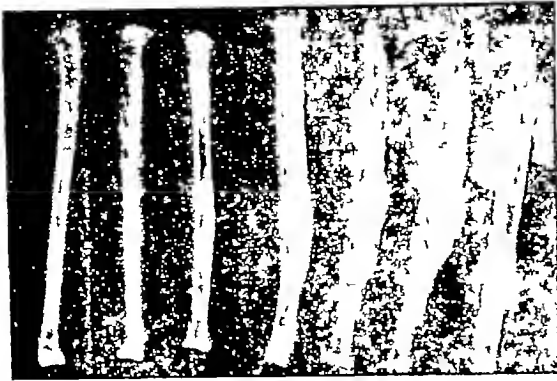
Roentgenograms of radii of osteopetrotic birds, normal bone on left
